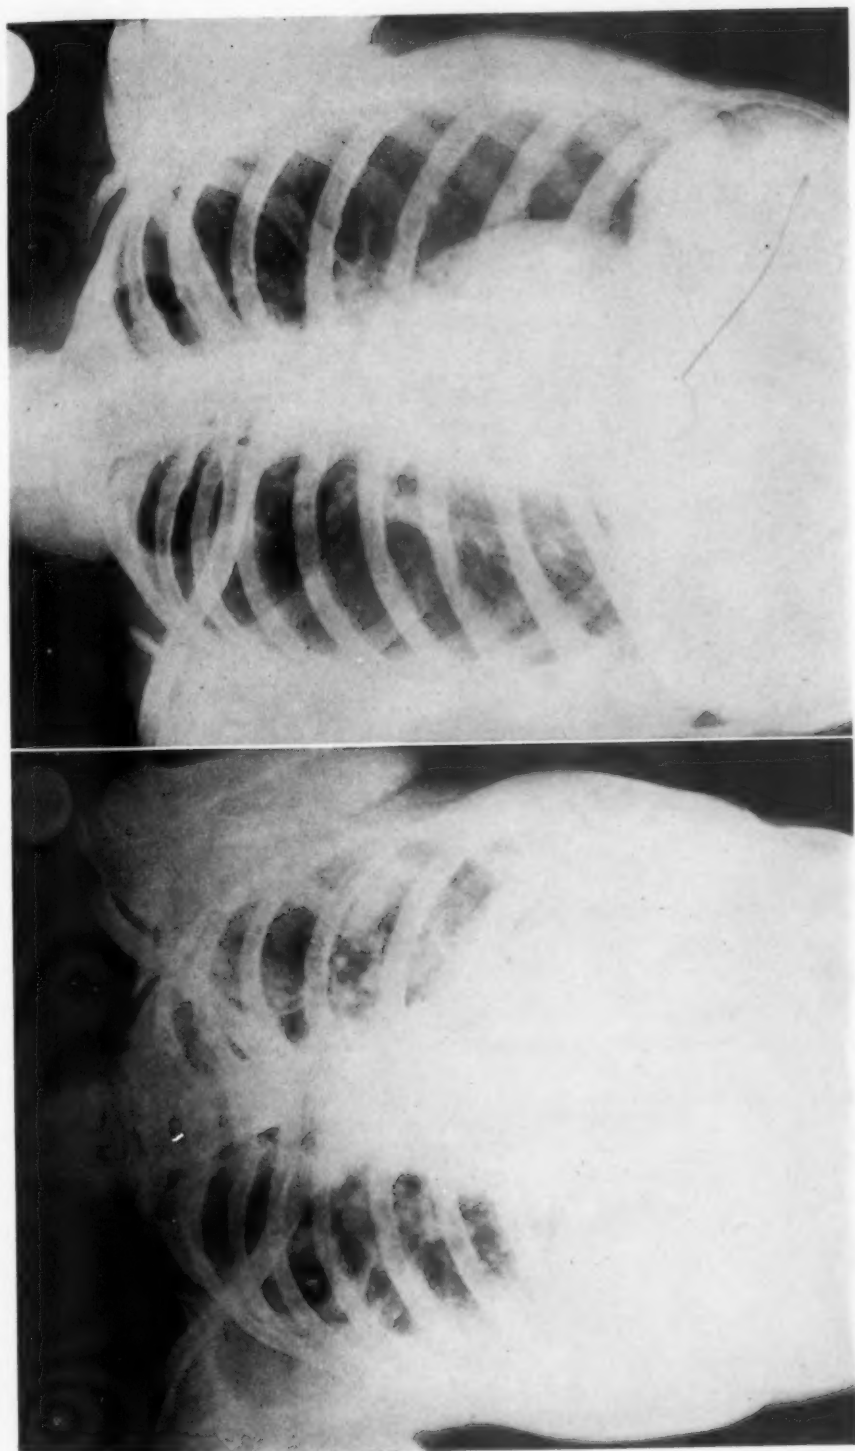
Case 1. Roentgenograms of the chest taken (*A*) on December 17, 1938, and (*B*) July 17, 1939.
